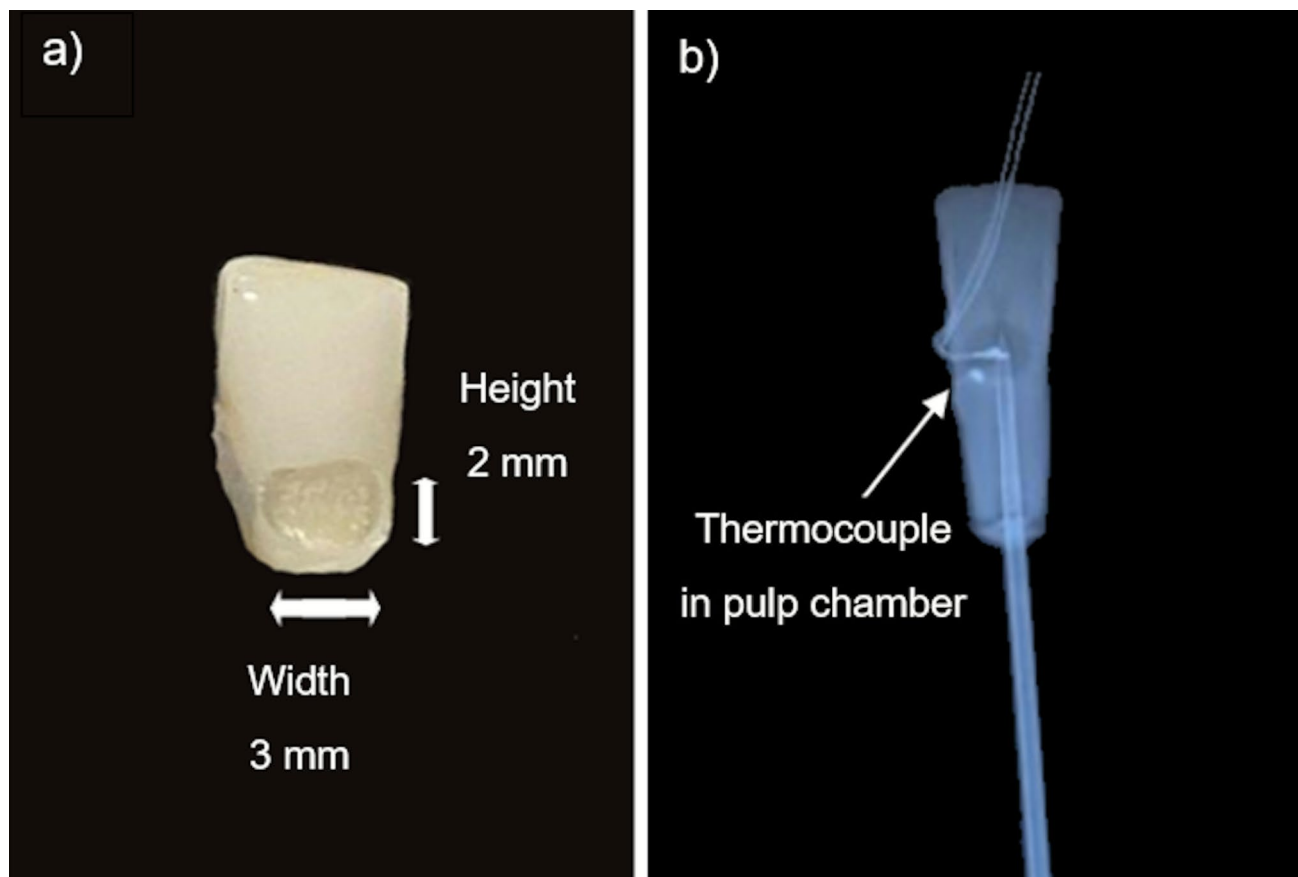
a Buccal Class V preparation on a lower incisor. b X-ray image of the Lower Central Incisor with the arrow indicating the thermocouple and the needle inside the pulp chamber
